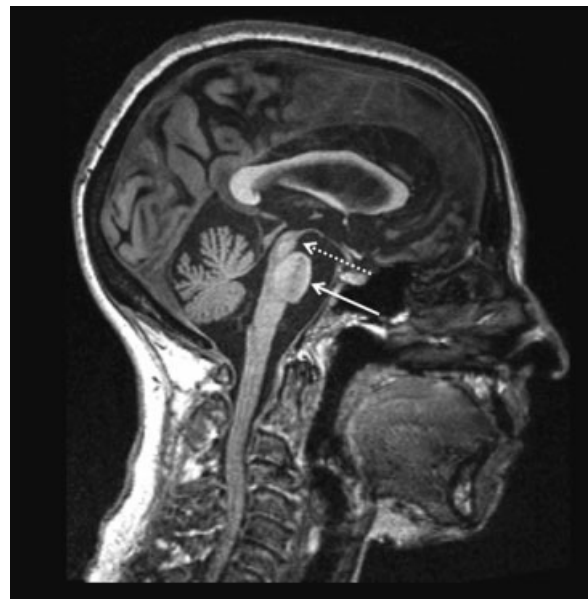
Sagittal T1-weighted magnetic resonance imaging in 63-year-old a patient with progressive supranuclear palsy, showing “hummingbird sign.” Atrophy of the midbrain tegmentum (arrow with dashed line) resembles a hummingbird head in the midsagittal plane, with a relatively preserved pons (arrow with solid line) that resembles the bird’s belly.
